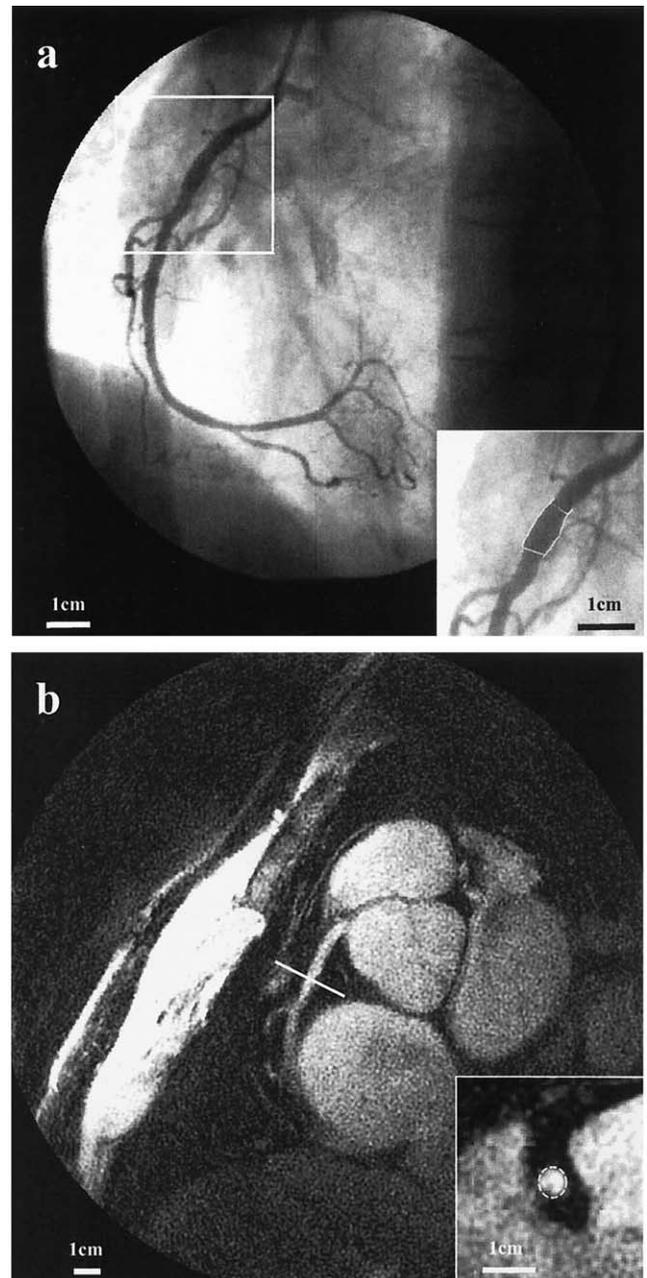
Quantitative analysis of corresponding X-ray coronary angiography (a) and coronary magnetic resonance angiography (MRA) (b) images of the right coronary artery showing the quantitative measurements of coronary size (X-ray: mean diameter = 4.1 mm; MRA: cross-sectional area = 19.8 mm², diameter = 5.0 mm).
